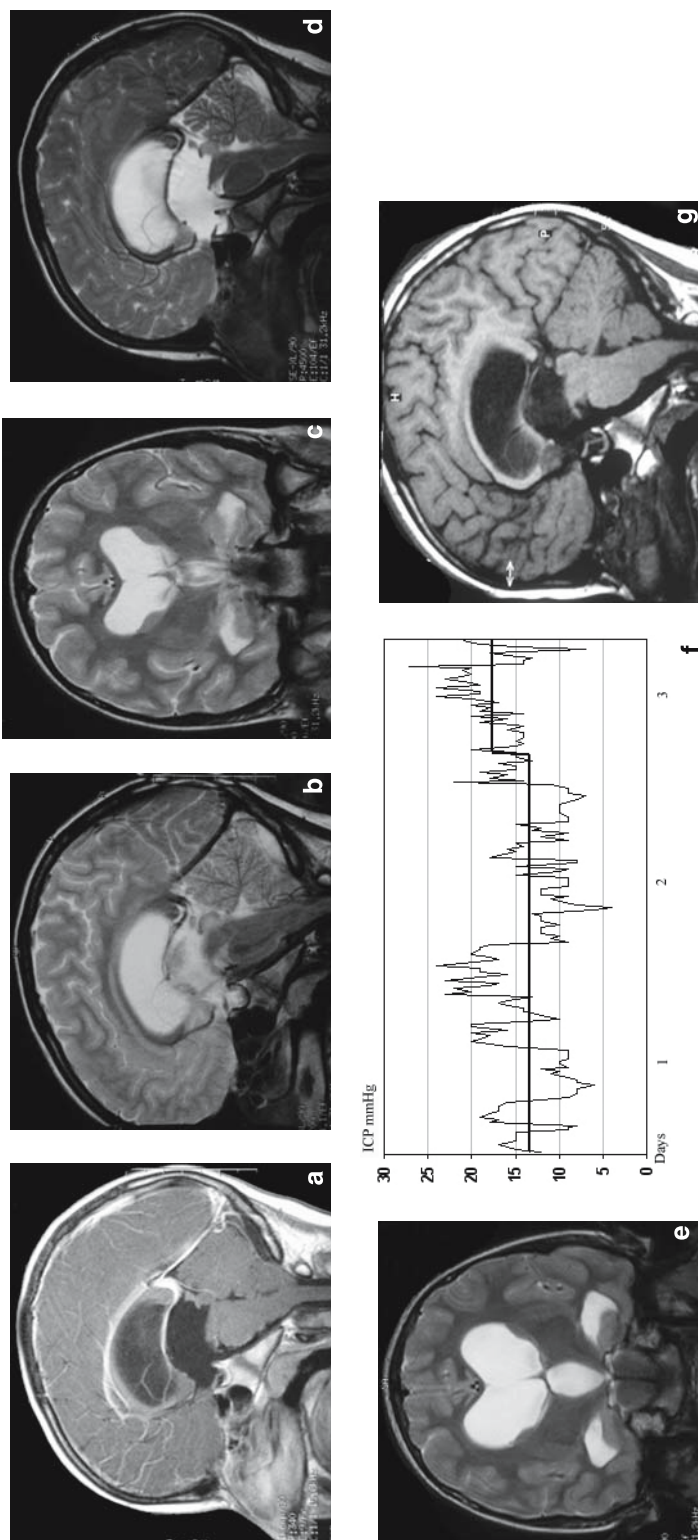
Eleven year old boy presenting with headache and papilledema: MRI reveals aqueductal stenosis due to a small tectal mass (a). Nine days following ETV, note the decreased third ventricular dilatation with decreased flattening of the mesencephalon and downward ballooning of the third ventricular floor (b, c). One year following ETV, third ventricle has returned to pre-operative shape and size, both in the sagittal (d) and coronal (e) view. ICP monitoring showed increased intracranial pressure with “plateau” waves (f). Patient was re-operated, ETV was found closed and re-opened. MRI performed one month after the second ETV (g) shows a large defect in the third ventricle floor and decreased volume of the third ventricle
